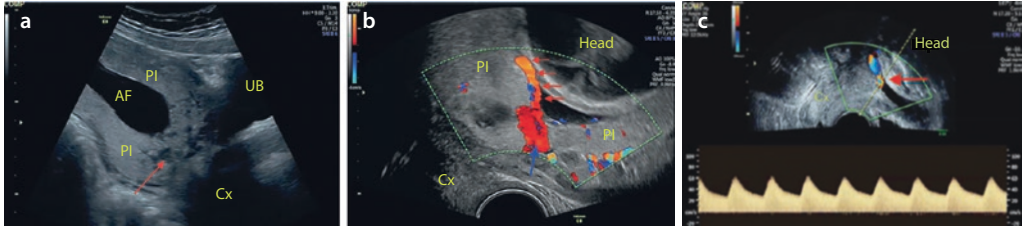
a–c Representation of the same pregnancy at different time points. a Abdominal sonography at 14 weeks gestation showing maternal bladder (UB), cervix (Cx), amniotic fluid (AF) and total placenta praevia (PI); lacunae (red arrow). b Vaginal sonography and color Doppler at 21 weeks gestation showing the cervix, placenta, and fetal head; large
